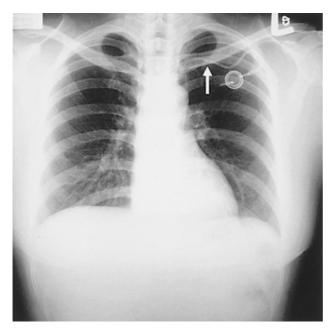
Chest X-ray shows minimal luminal narrowing of the catheter (arrow).
